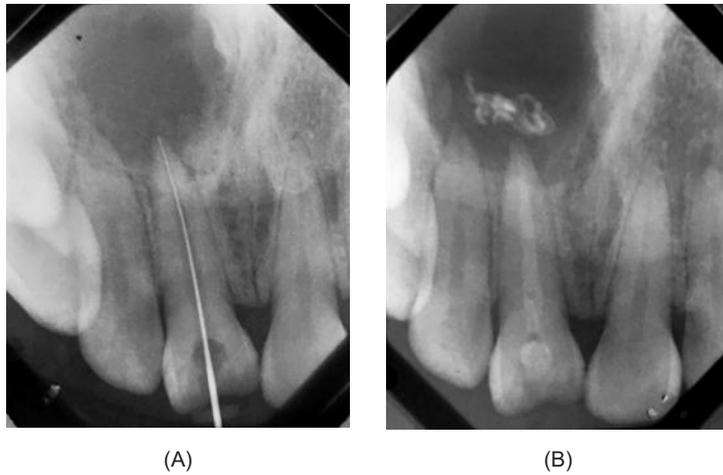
A. measurement of working length 11. B. radiograph after dressing
